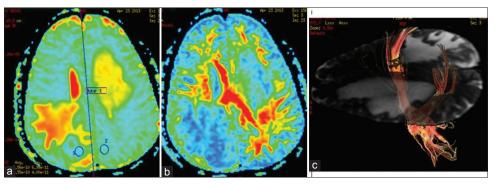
The apparent diffusion coefficient (map) demonstrated the lesion extents in (a), and the fractional anisotropy was lower in the lesion (b), while the diffusion tensor magnetic resonance imaging tractography showed ejection of the white matter fibers (c)
